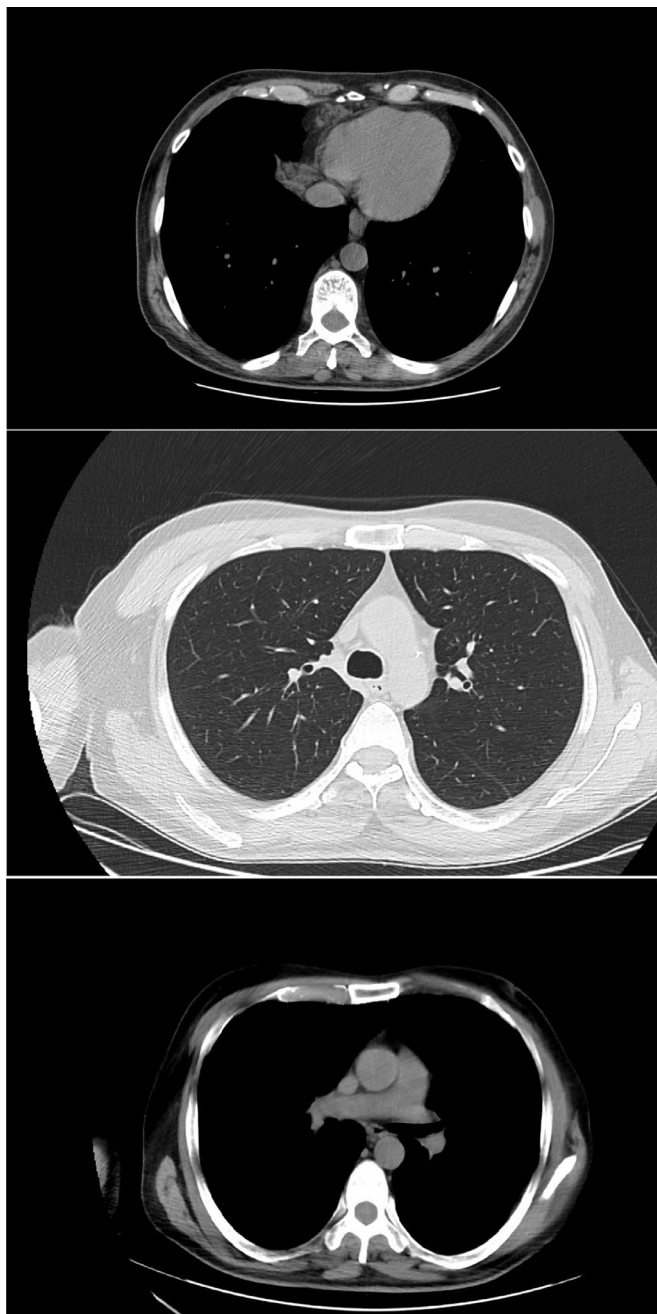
Chest CT scan demonstrates no abnormal findings except infiltrative and hypodense lesions in the right cardiophrenic angle.
